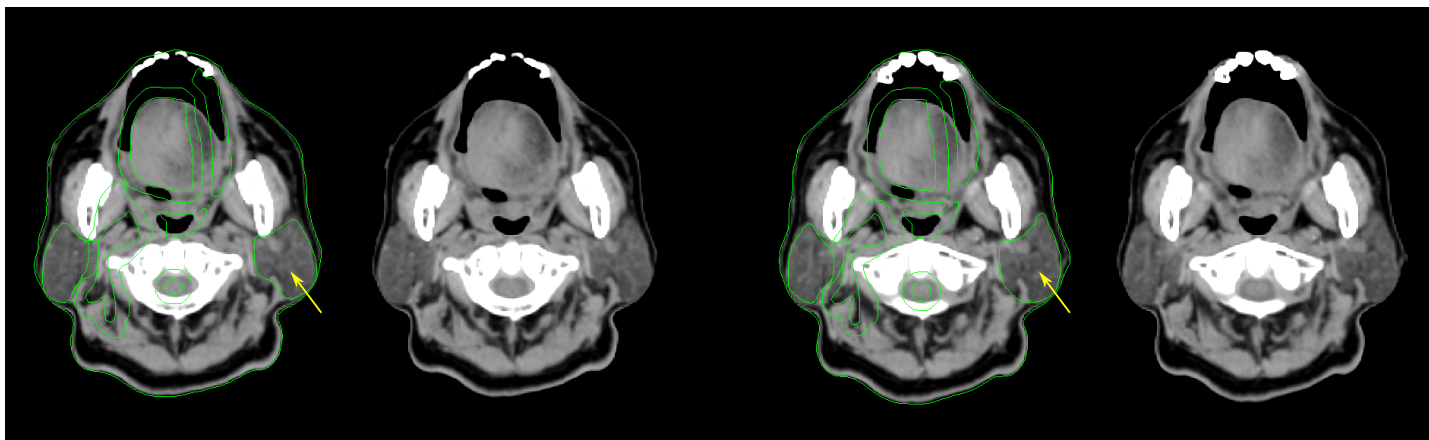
Two example BCCA routine axial CT images (at 120 kVp and 350 mA) showing parotid contours around 2cm inferior to the ear canal. The left parotid is indicated in each, and a view with and without ROI is shown to demonstrate tissue contrast differences. Other ROI include the pharynx, spinal cord and margin, clinical and planning target volumes encompassing the tongue and right nodes, and a portion of the left oral cavity that has been subtracted from the target volume for sparing purposes.
